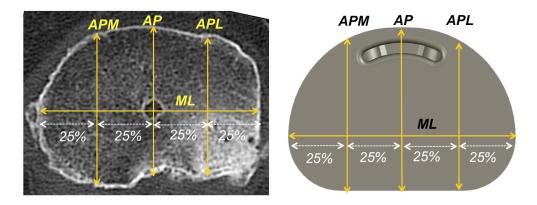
Measurements of the ML, AP, APM and APL dimensions done on the CT scan with the corresponding dimensions of the implanted tibial component.
